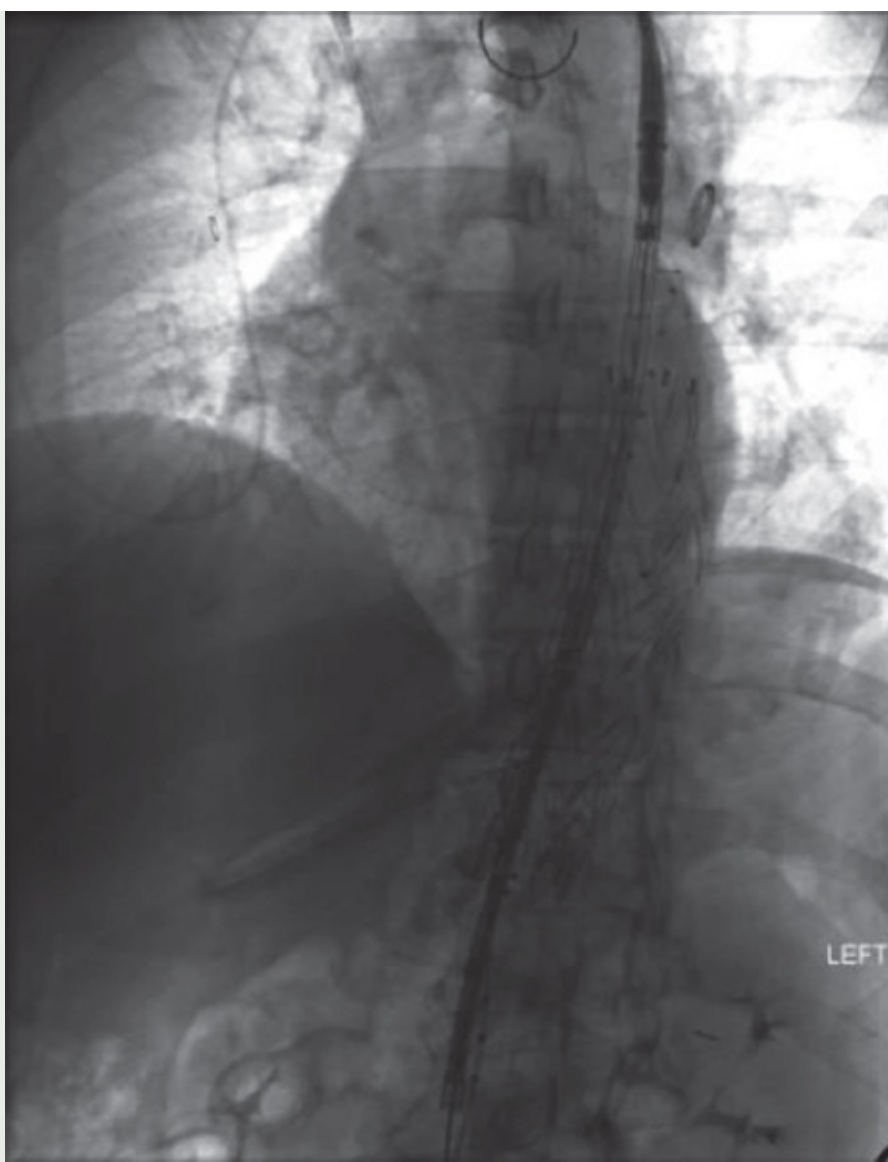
Intravascular ultrasound examination (not shown) confirmed the location of the large saccular aneurysm with no evidence of intramural hematoma or acute dissection. Thoracic aortography shows undeployed endograft centered on bilobed aneurysm in the distal descending aorta.
